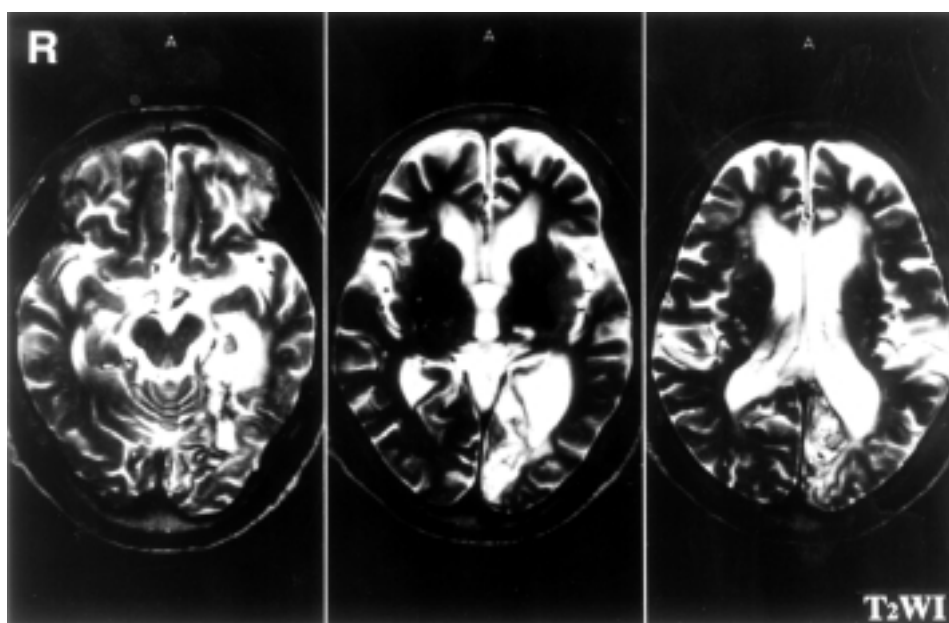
T2-weighted MRI of the brain.
